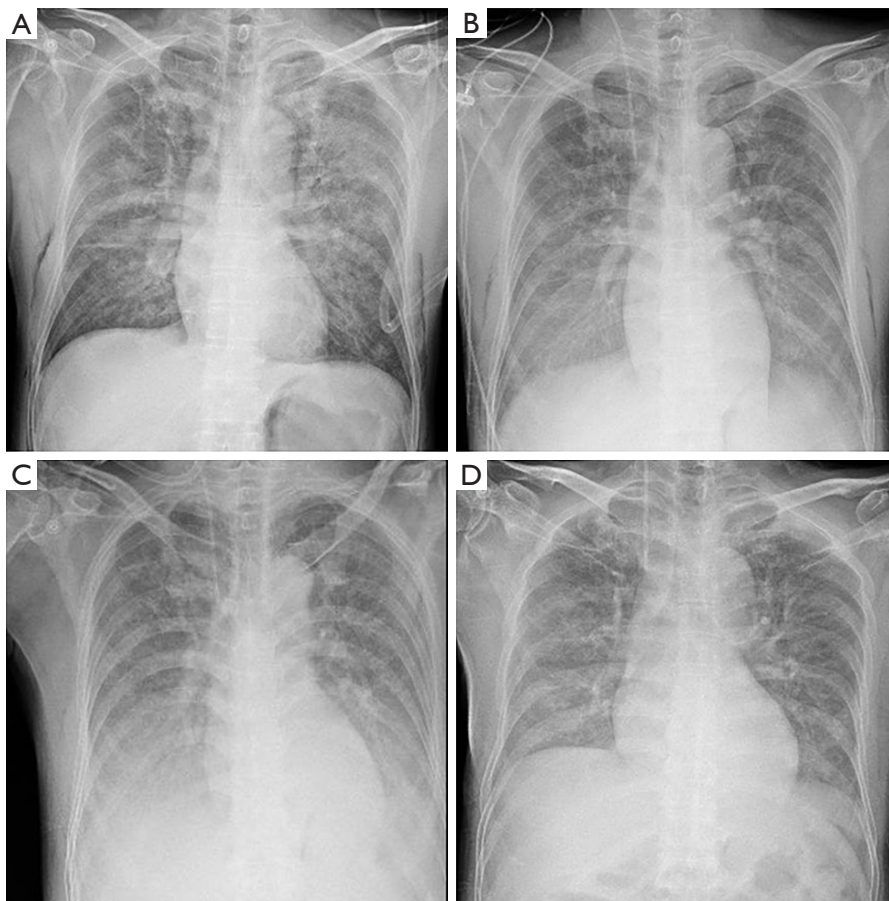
The pulmonary imaging changes in ARDS due to carbon dioxide gas embolism. (A) Two-hour postoperative chest radiograph shows mild exudate in both middle lungs and pneumatization of the soft tissue of the chest wall. (B) Twelve-hour postoperative chest radiograph shows progression of exudate in both lungs. (C) Sixty-hour postoperative chest radiograph shows more severe pulmonary lesions. (D) Eighty-four-hour postoperative radiograph shows substantial resorption of pulmonary lesions. ARDS, acute respiratory distress syndrome.
